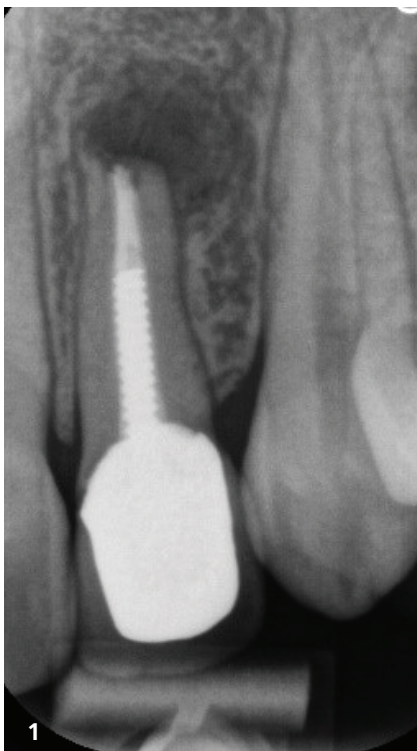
Periapical radiograph showing failed orthograde root canal treatment with apical radiolucency. Fig. 2: CBCT section showing the extent of the radiolucency and the residual bone ridge volume. Fig. 3: CBCT showing incisive foramen and its association with affected tooth. Fig. 4: Further CBCT view showing adjacent root positions.
